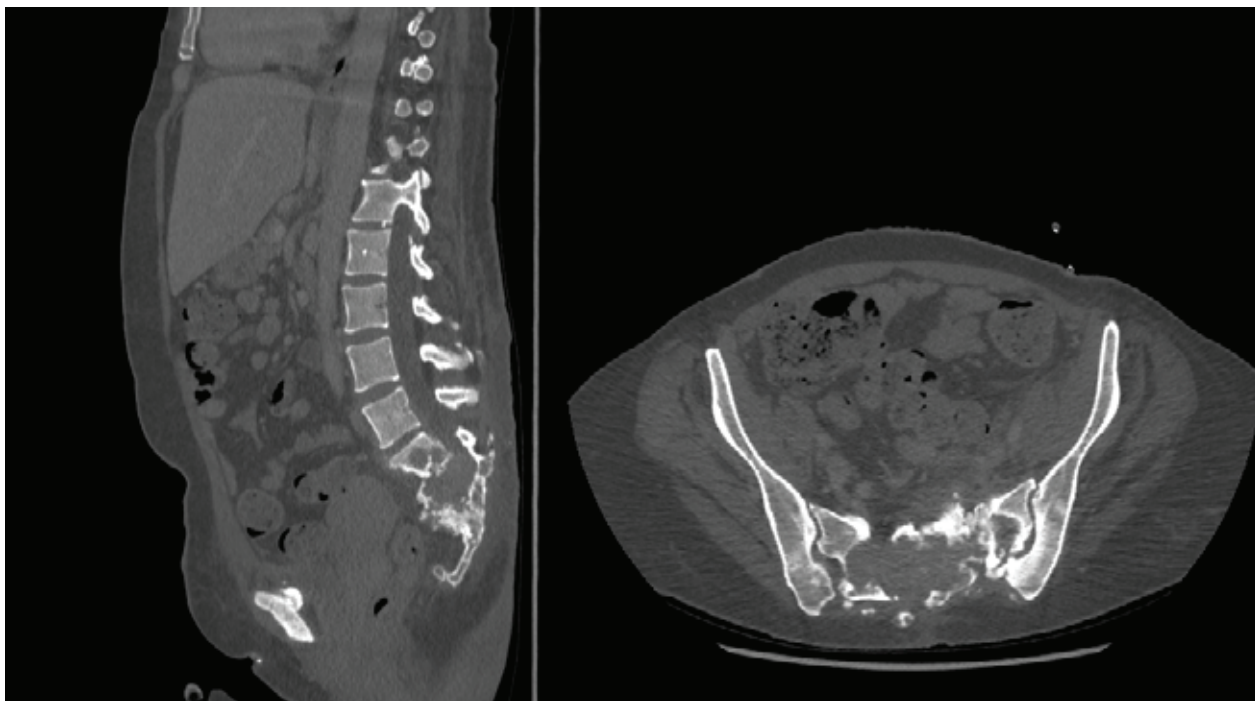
(A, B) The CT scan images show a large defect involving virtually the entire sacrum with a large soft tissue mass with destruction of cortical bone.
